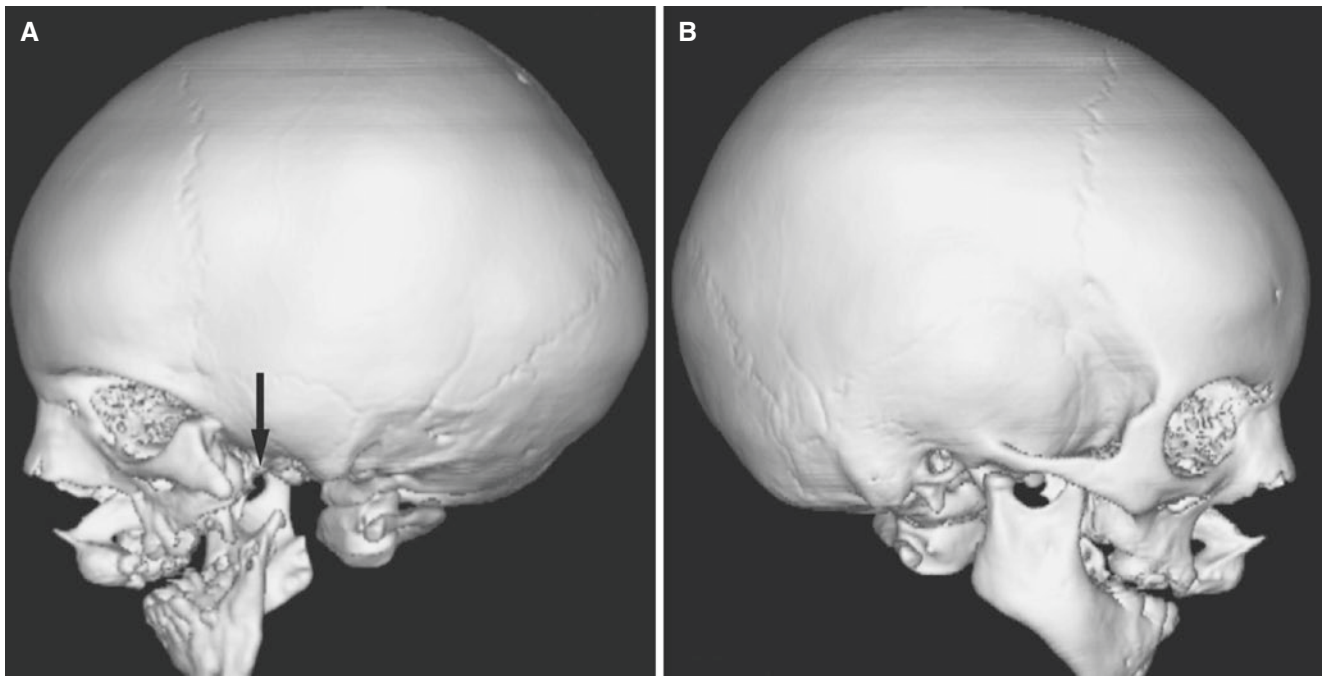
Hemifacial microsomia; 4-year-old male with multiple anomalies including cleft palate and lip. (A) 3D CT image, lateral view, shows left-sided severely hypoplastic mandible and absent zygomatic
